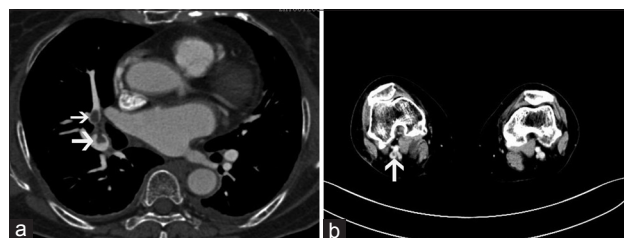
(a) Transverse contrast-enhanced computed tomography (CT) image obtained at the level of the left atrium in a 69-year-old woman 6 days after gynecological pelvic surgeries for ovarian cancer shows a filling defect in the right middle lobe and right basal segmental pulmonary artery (arrows). (b) Transverse CT venography in the same patient: CT image at the level of the knee shows thrombus in the right popliteal vein (arrow).
